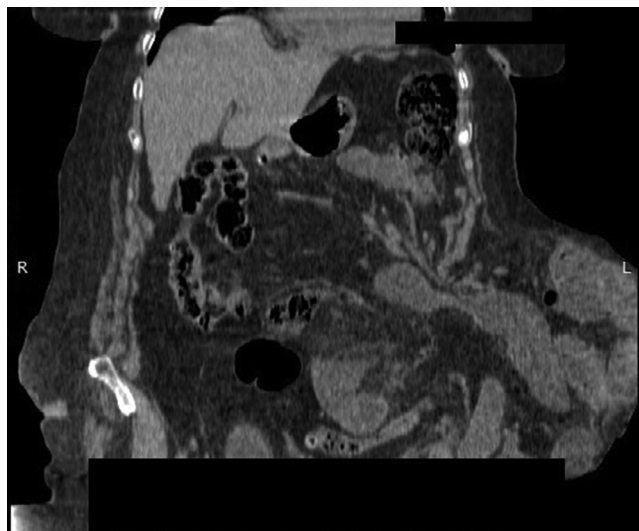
Axial CT scan of the abdomen demonstrates hernia sac with incarcerated intestinal loops and signs of mechanical obstruction. The hernia defect shows intestinal incarceration (yellow ellipse). Calcified foreign body is visible in the abdominal wall (yellow arrow).
